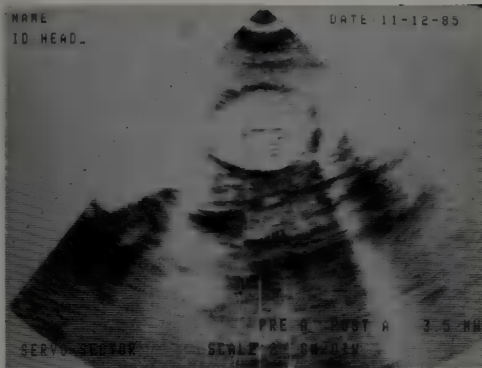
Ultrasonography. Biparietal diameter of 4.6 cm, consistent with a 20.4 week gestation.
